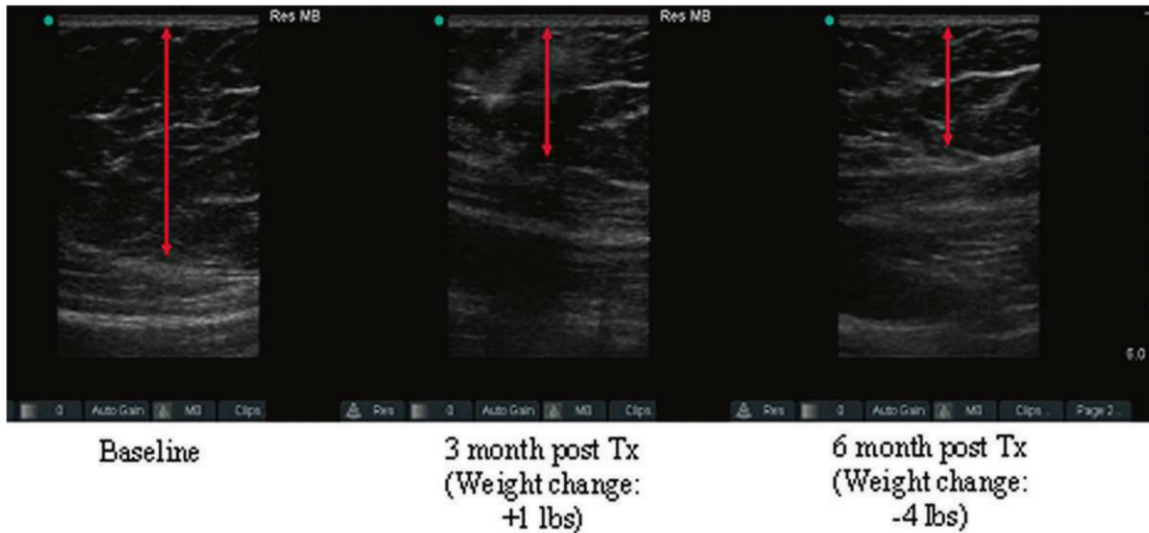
Ultrasound images of adipose layer before and post Tx. Ultrasound images were taken from the same patient at the same site over a 6-month period. The arrow demonstrated the thickness of the adipose layer.
